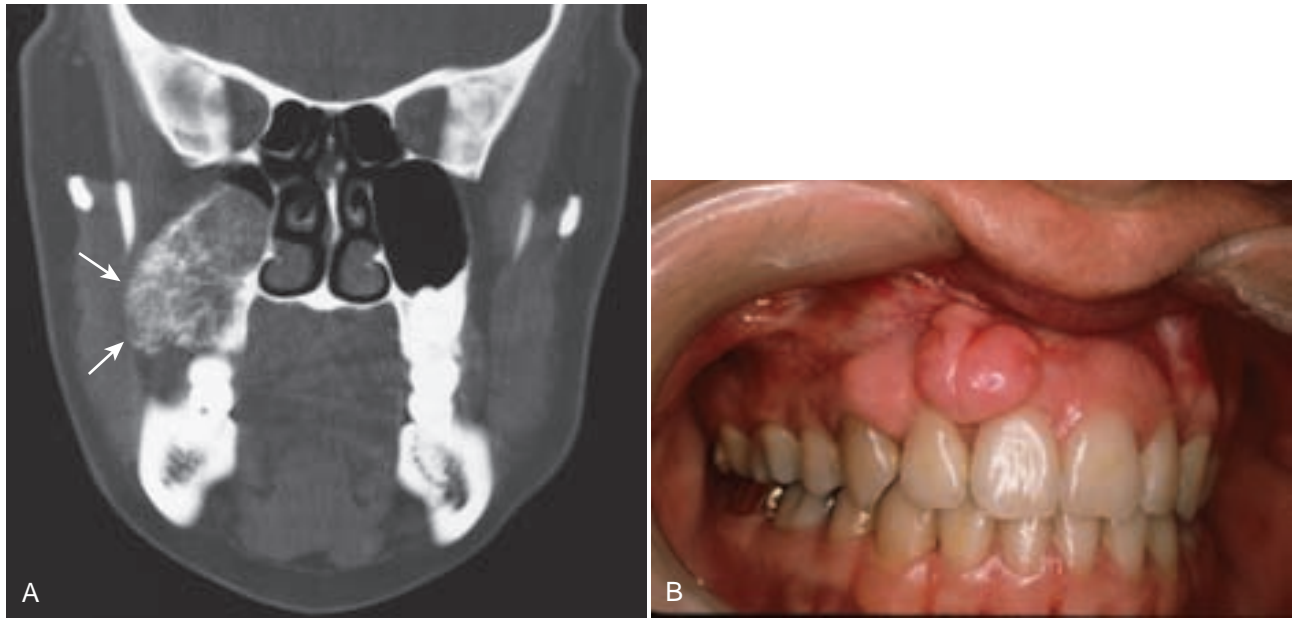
A, Intramedullary osteosarcoma. Coronal CT shows bone-producing tumor of the right maxilla with delicate bone spicules. B, Parosteal (low-grade) osteosarcoma. Exophytic, nodular tumor on the surface of the bone. (A, From White SC, Pharoah MJ: *Malignant diseases of the jaws*. In: *Oral Radiology, Principles and Interpretation*. 6th ed. St. Louis, Mosby, 2008; B, Courtesy of Department of Diagnostic Sciences, Baylor College of Dentistry, Houston, Tex.)
